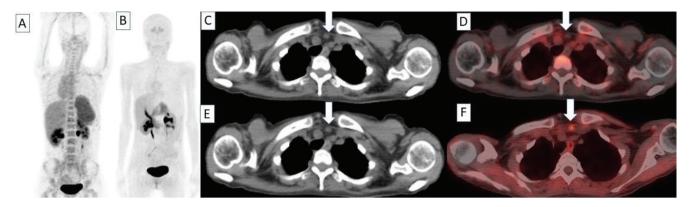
⁶⁸Ga- DOTATATE and ¹⁸F-FDOPA PET/CT images of patient number 5. Forty-five years old female diagnosed with MEN IIA syndrome (medullary thyroid carcinoma and adrenal paraganglioma) was referred with elevated serum calcitonin levels (1372 pg/mL) following total thyroidectomy. On maximum intensity projection (A, B), axial CT, and fusion images of ⁶⁸Ga-DOTATATE (C, D) and ¹⁸F-FDOPA (E, F) PET/CT studies, focal pathological ¹⁸F-FDOPA uptake was detected on a nodular lesion located in the thyroid bed (SUV_{max}: 2.2), which was ⁶⁸Ga-DOTATATE negative (arrows). A biopsy revealed local recurrence in the thyroid bed
